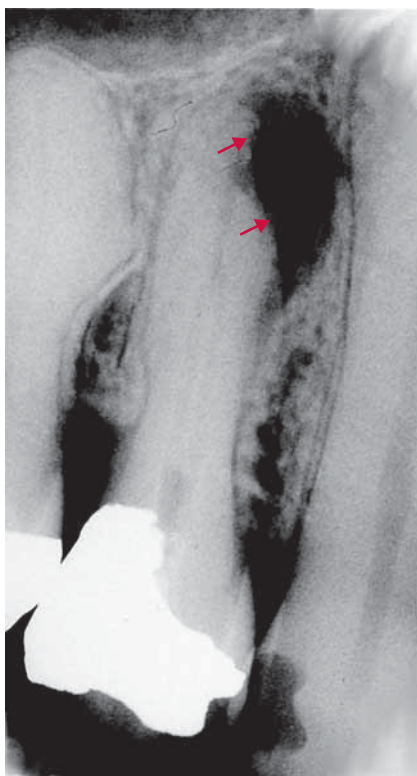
Periapical radiolucency. Radiograph of a maxillary first premolar with the dark area (*red arrows*) surrounding the root apices indicating the pulp has become necrotic. A granuloma or cyst has developed in the bone, probably as a result of the exposure of the pulp to deep decay that was removed and restored with a large amalgam filling (seen as a white outline) that covers the distal and occlusal surfaces of this tooth.
